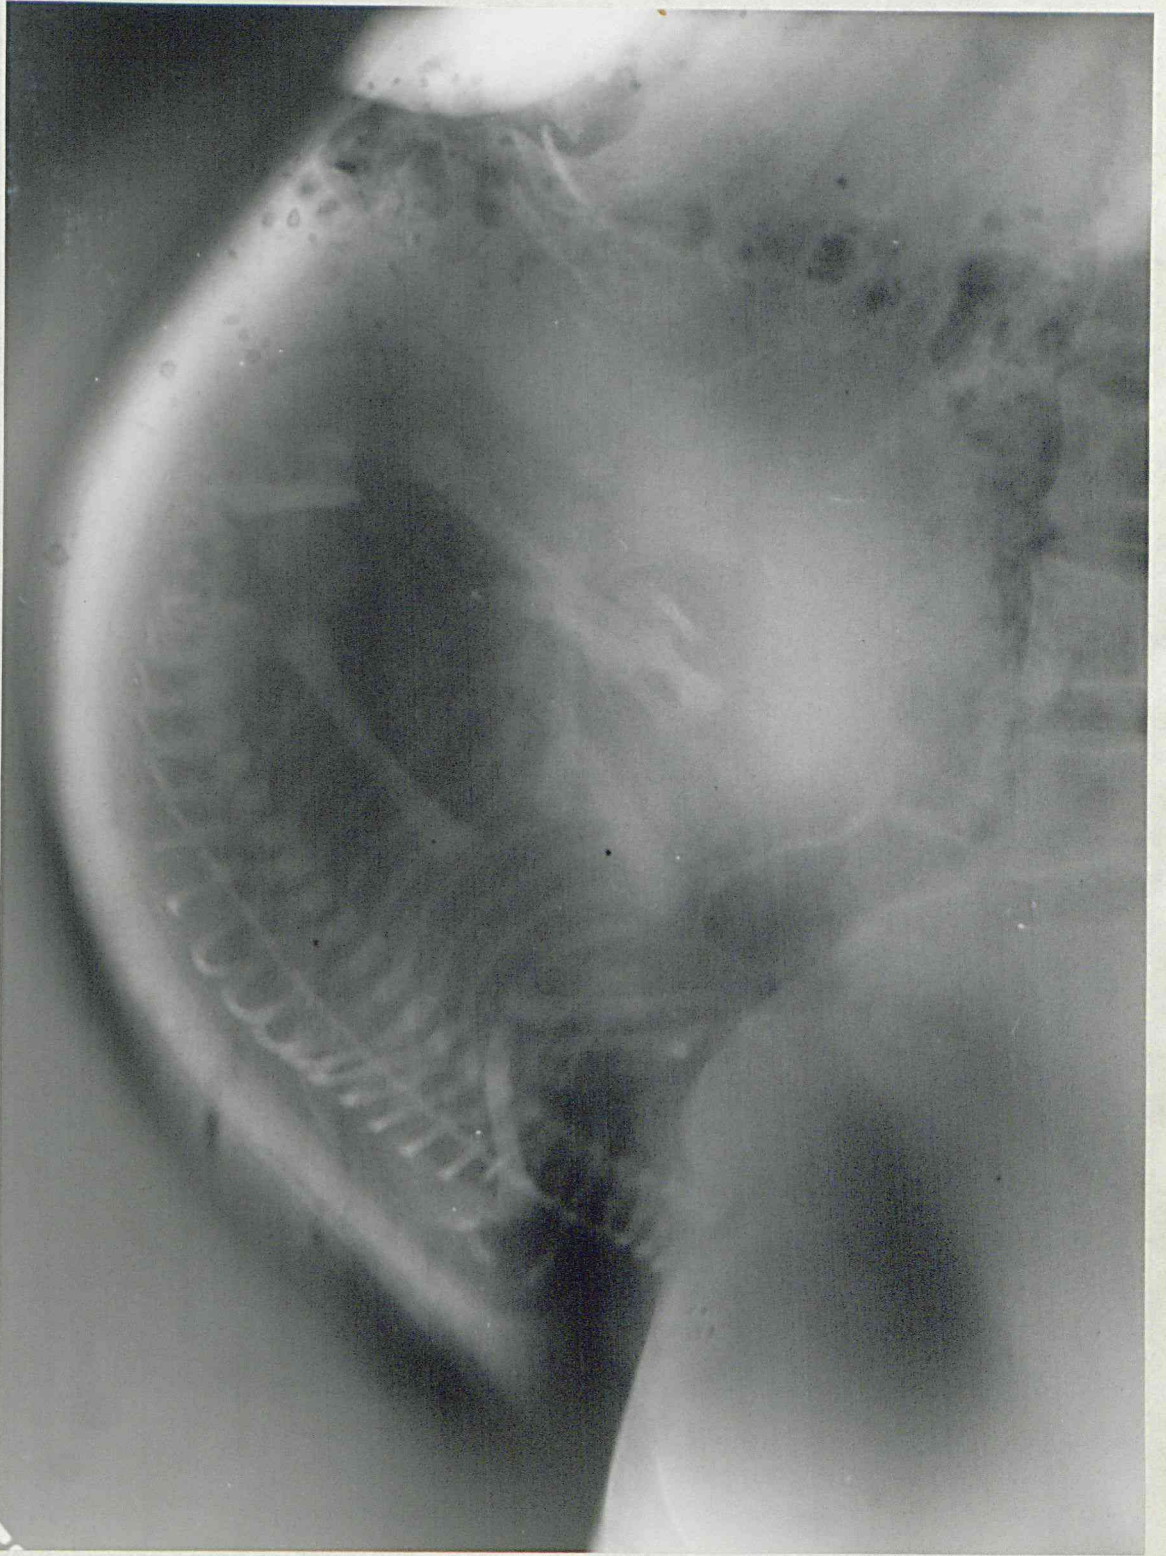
Soft tissue radiography - the lateral radiograph of the abdomen. Posterior implantation of the placenta in the upper uterine segment shown as a unilateral thickening of the soft tissue shadow of the uterus. (Case No. 215).
